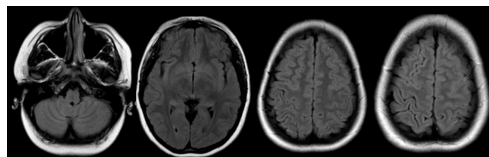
MRI performed two months later: shows superficial siderosis secondary to cSAH and resolution of white matter hyperintensities.
